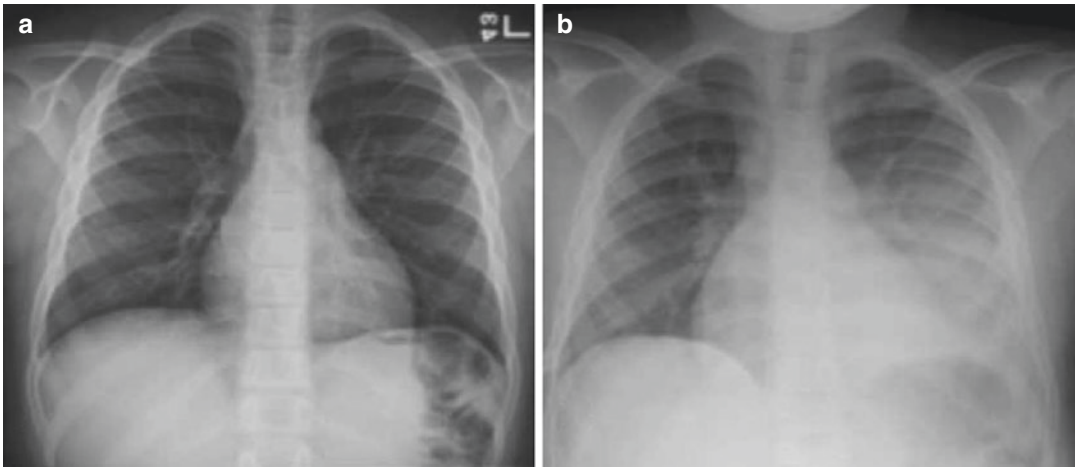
Acute chest syndrome (ACS) shown in chest X-ray in 12-year-old schoolchild with ACS (a) at admittance caused by coronavirus (CoV), and (b) after ACS has been established
